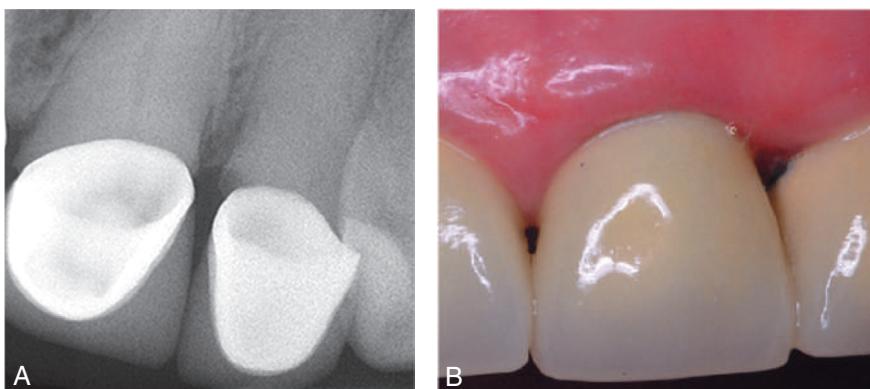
Open margins noted on mesial and distal maxillary left central and lateral incisors result in a significant inflammatory response with bone loss and destruction of the interdental papilla. (A) Radiographs. (B) Appearance.
